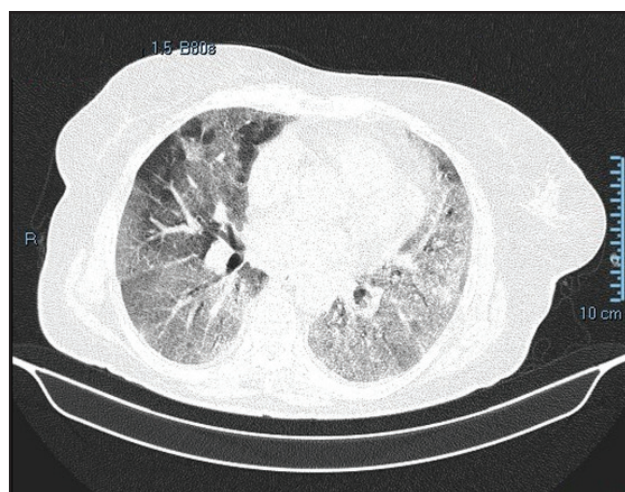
Pulmonary CT scan native in the 7th day of hospital admission compared to the investigation performed in the first day of hospital admission, highlights bilateral pulmonary fibro-alveolar-interstitial modifications in the context of SARS-CoV-2 pneumonia in marked progression, with current severity score of 21.
